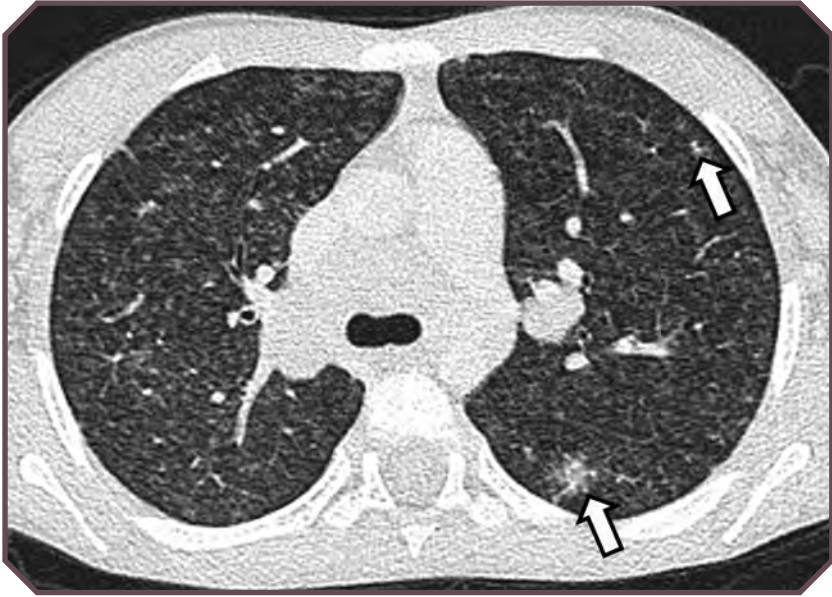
Granulomatous lymphocytic interstitial pneumonitis in a 17-year-old boy with pneumonia complicating common variable immunodeficiency. Axial chest computed tomographic image demonstrates increased interstitial lung markings with superimposed pulmonary nodules (arrows). The diagnosis was confirmed via lung biopsy.
